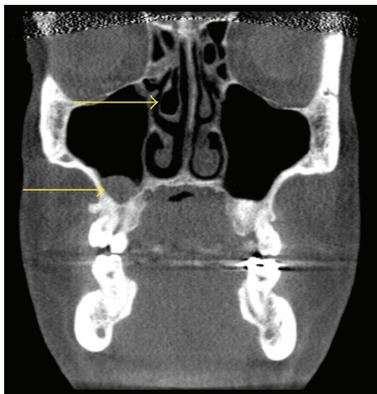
Coronal CT scan demonstrating right middle concha bullosa (superior arrow) and right maxillary sinusitis (inferior arrow). No nasal septal deviation is present. Note the difference in size of the right middle concha compared to the left middle concha.
